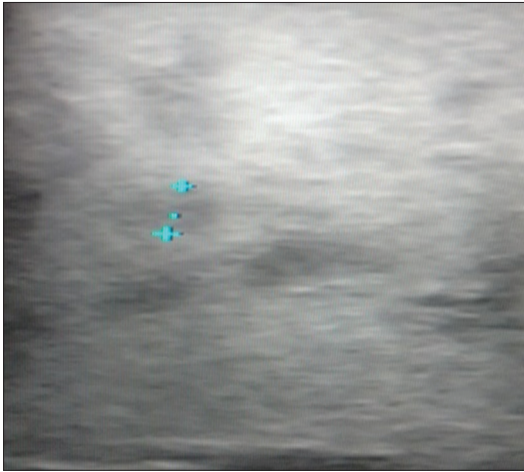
Ultrasonography of liver showing multiple microabscesses largest measuring 1.5 cm.
